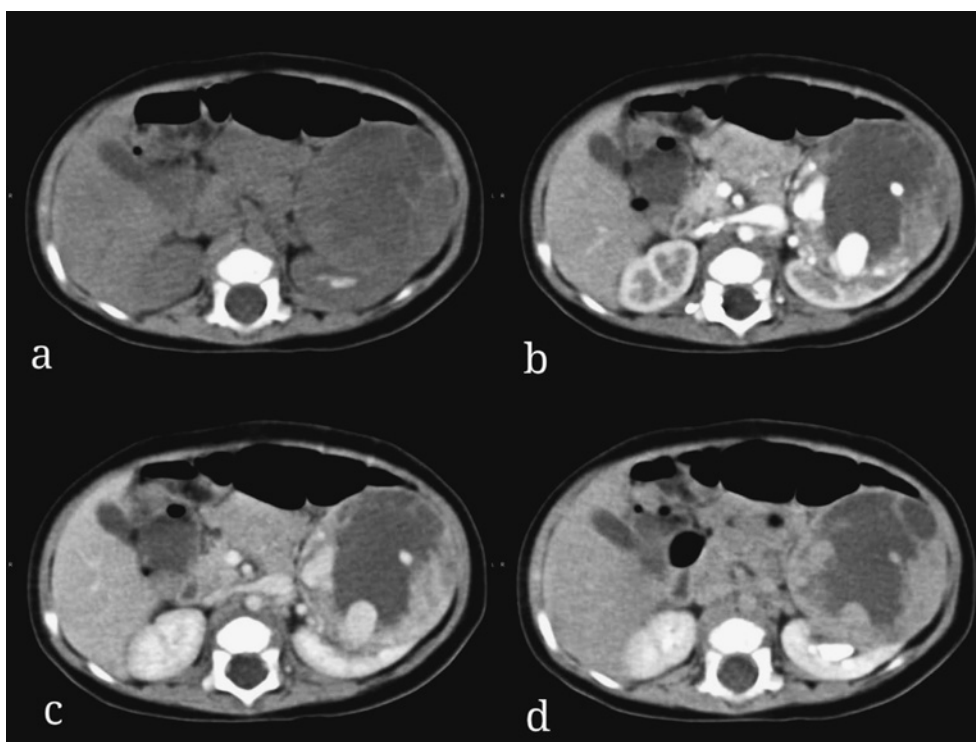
An unenhanced CT scan showed a heterogeneous solid mass bulging out of the renal parenchyma (Fig. 2a). The mass showed obvious heterogeneous enhancement on the corticomedullary phase (with necrosis in the center and many vessels in the edge), continued enhancement on the nephrographic phase, and slight wash-out on the delayed phase (Fig. 2b, c and d).
